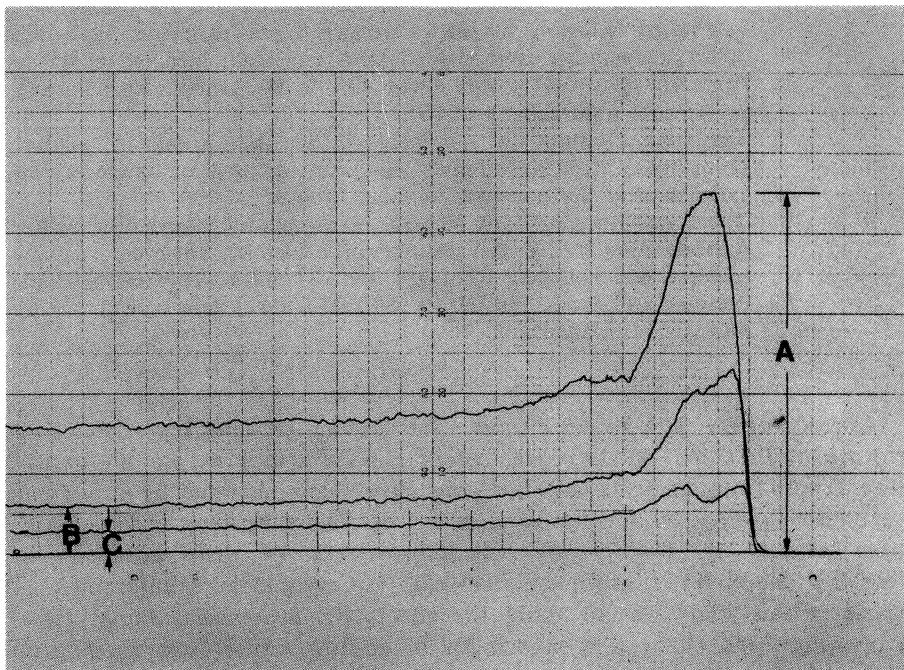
Time-activity curve in ^{201}Tl myocardial scintigraphy
